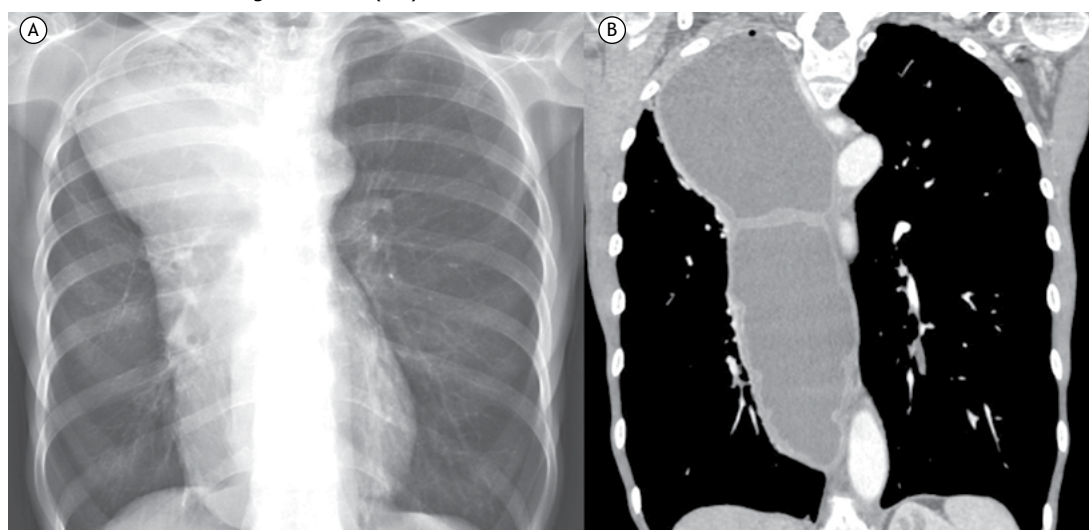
In A, posteroanterior chest X-ray showing widening of the mediastinum on the right. In B, coronally reconstructed CT scan of the chest revealing a markedly dilated esophagus with hypodense intraluminal contents consistent with food debris. Also note tapering of the distal esophagus.
